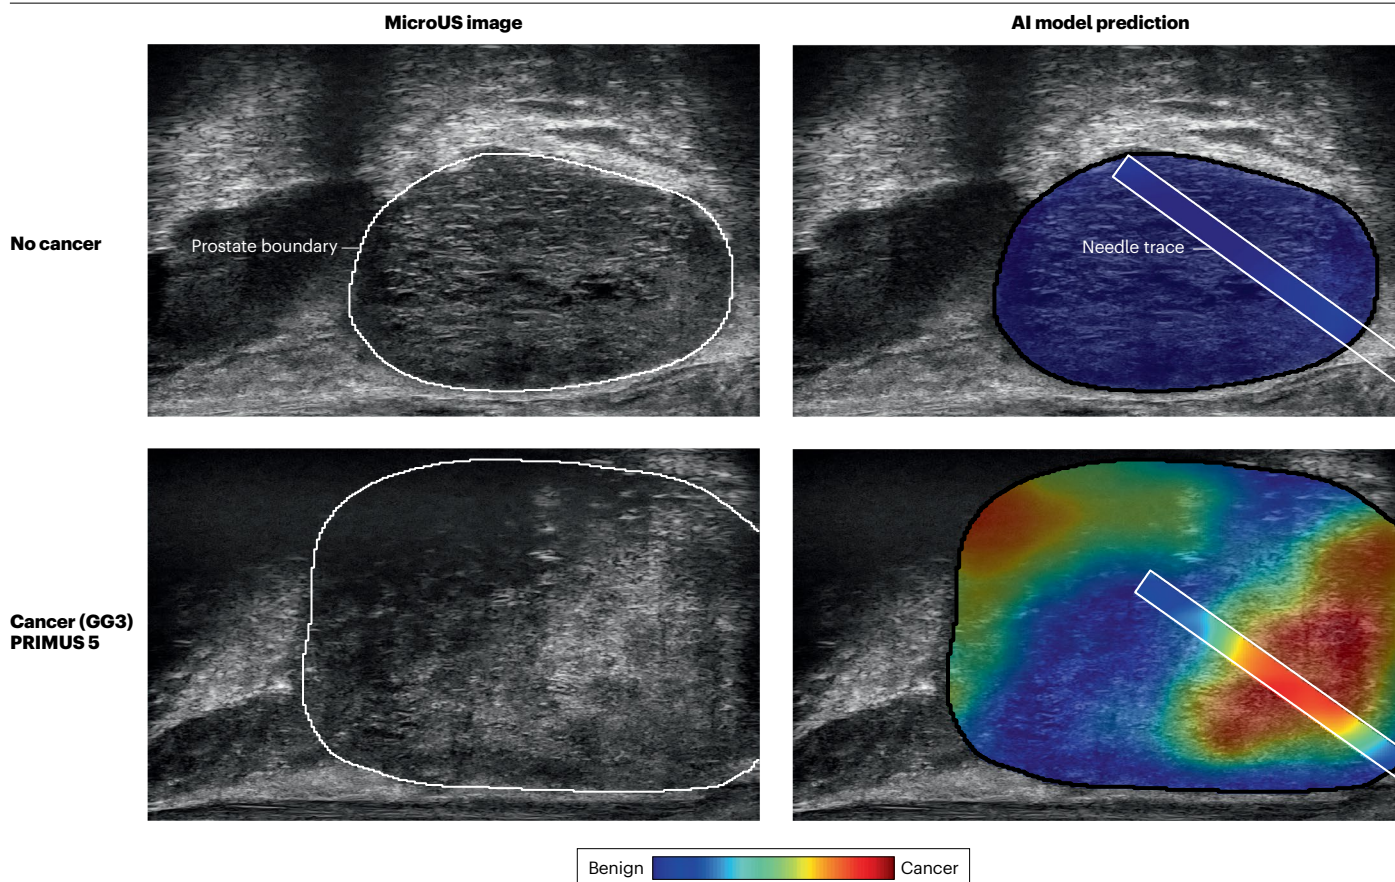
Example of artificial intelligence-generated predictions of micro-ultrasound images. Example heat maps generated by using the ProstNFound artificial intelligence (AI) model for micro-ultrasound (microUS) are shown. The top panels show an example of benign prostate imaging on
